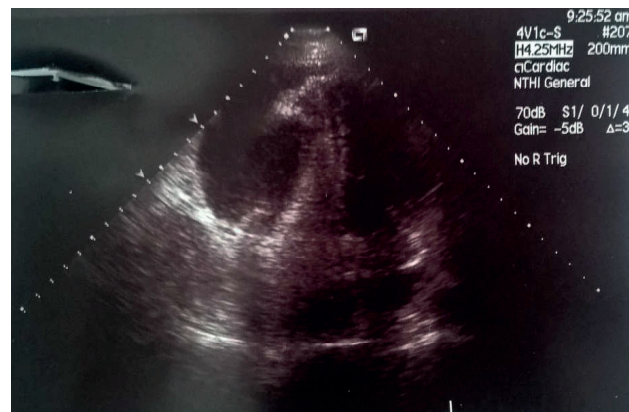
Transthoracic echocardiography (TTE) that shows free fluid by the lateral wall of the right ventricle and compression of it
